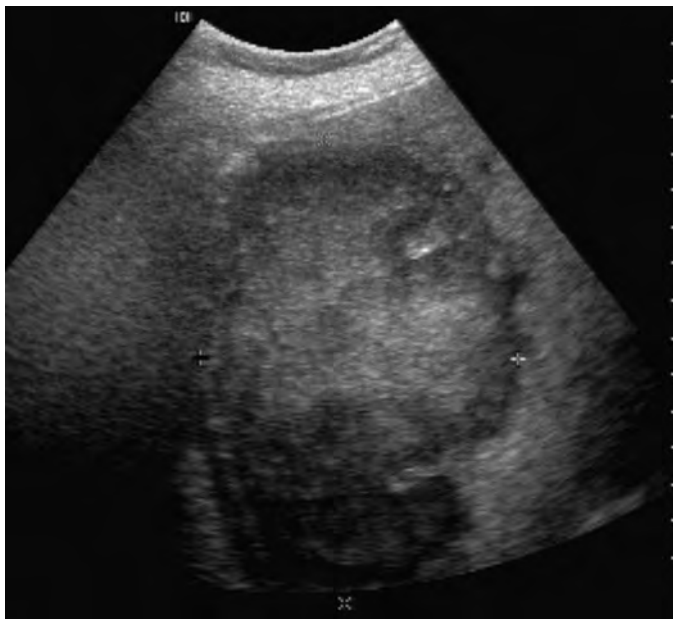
Amebic abscess: sonographic features. A large, well-defined abscess is identified in the right lobe of the liver.
